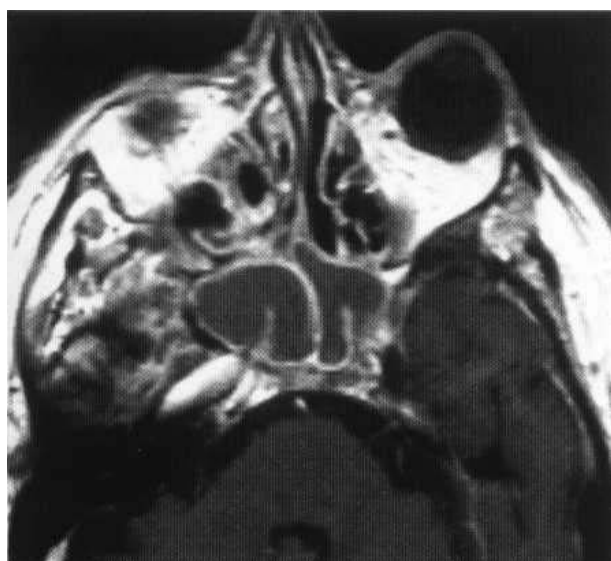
Axial T₁-weighted gadolinium-enhanced MRI of a sphenoid mucocele demonstrates an expanded rim enhancing sphenoid sinus containing fluid-density material.
